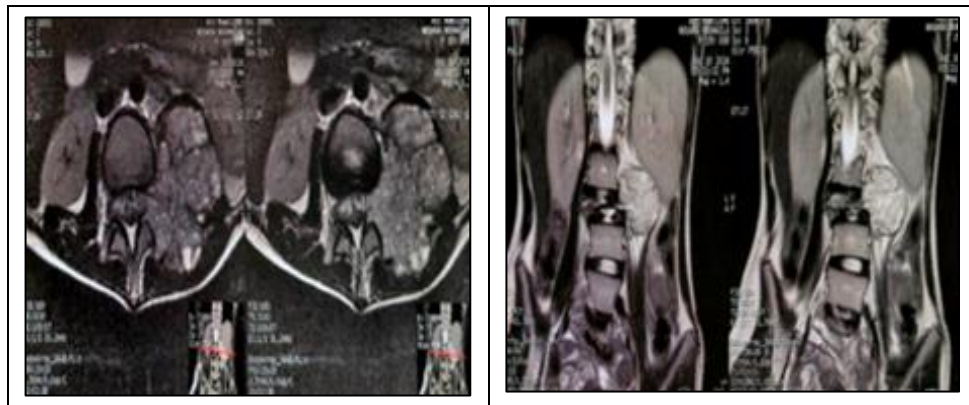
MRI demonstrating heterogeneous lesion with fluid-filled cavities
